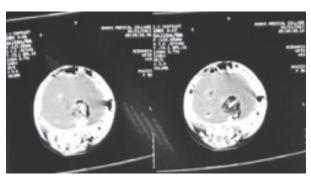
CT scan showing intra-abdominal fetiform mass
